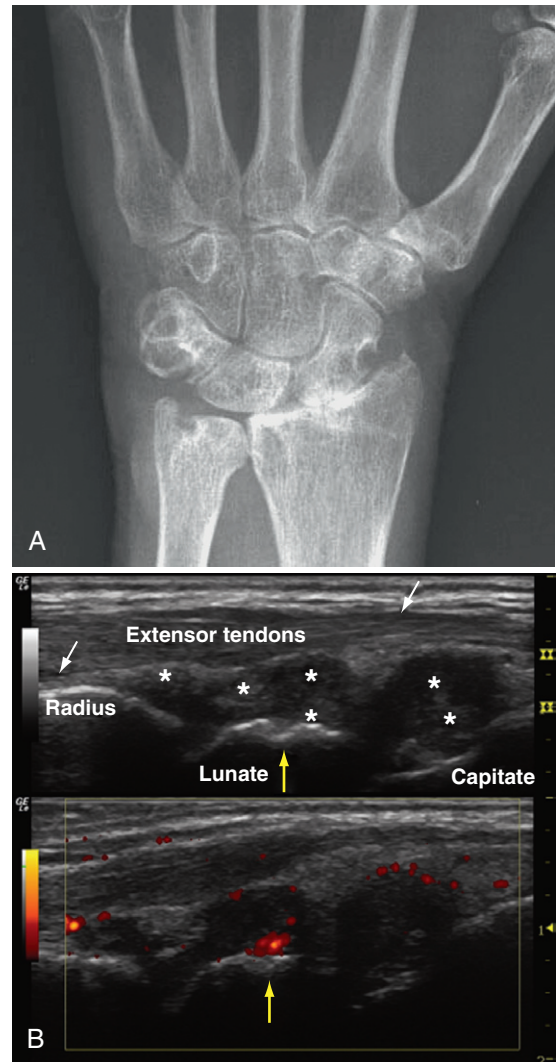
A, Typical sites of osseous erosion shown on radiographs of a rheumatoid wrist include triquetrum, pisiform, scaphoid, and radius. Erosions are also seen at the ulnar aspect of the distal radius and the distal ulnar styloid process secondary to involvement of the inferior radioulnar compartment. Diffuse cartilage loss is evident in the radiocarpal compartment. B, Ultrasound of the rheumatoid wrist dorsal longitudinal view shows synovial proliferation (*), tenosynovial thickening (white arrows), synovitis, and synovial hyperemia (yellow arrows). Upper panel, grayscale; lower panel, power Doppler mode. (A, Courtesy Dr. Barbara Weissman. B, Courtesy Dr. Arnoldas Ceponis.)
